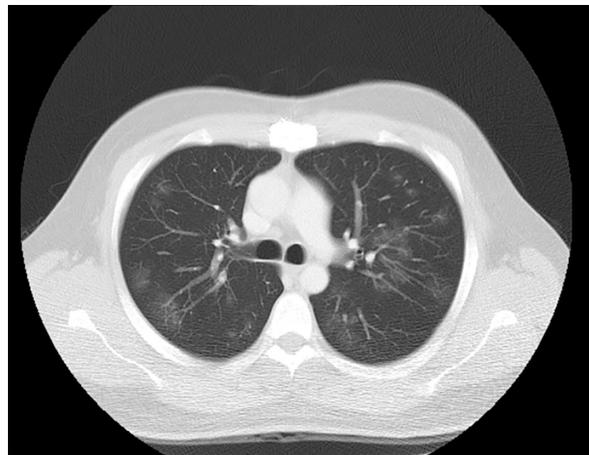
Thoracic computed tomography scan revealing ground-glass opacities in 25% of pulmonary parenchyma.
